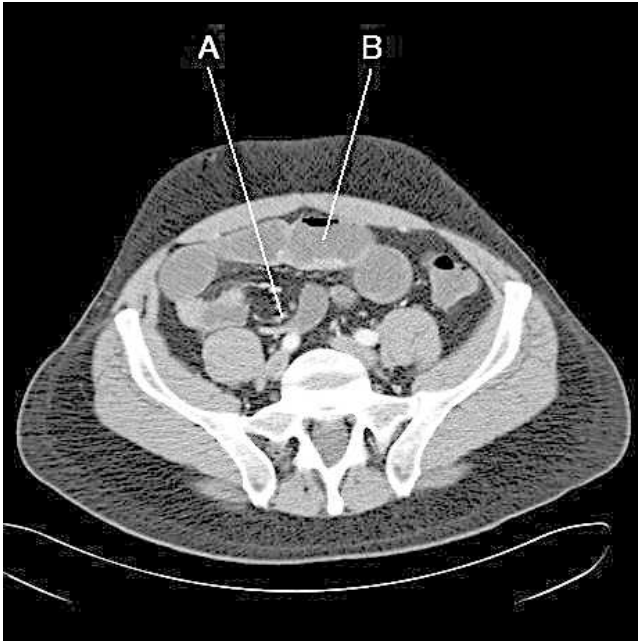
Representative CT scan.
